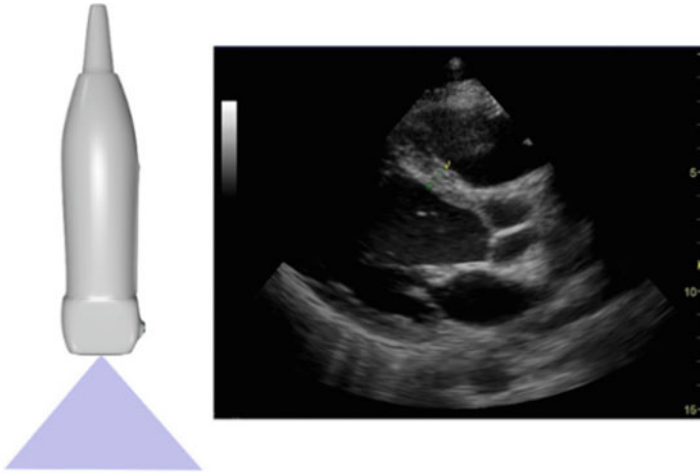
Sector probe. Note the small footprint of this probe and the sector display. The image is a parasternal long axis view of the heart
